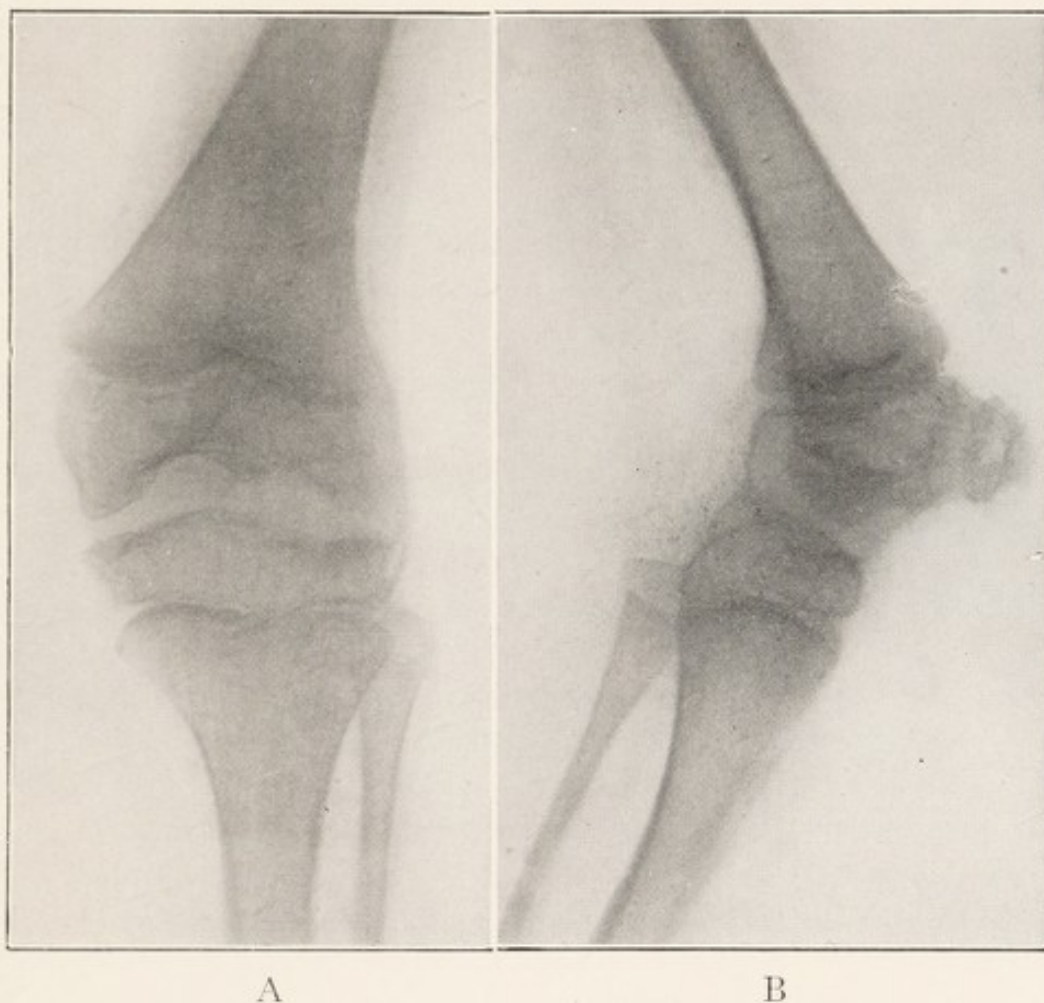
X-RAY SHOWING ACUTE INFECTIOUS ARTHRITIS OF KNEE, LATE STAGE, ANTEROPOSTERIOR VIEW.
